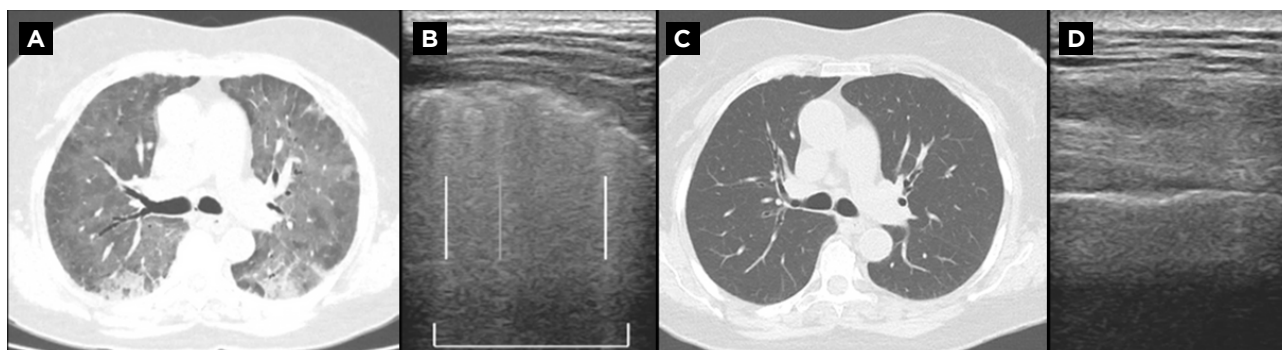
Baseline and Follow-up Imaging in MTX-Associated Pneumonitis. Axial high-resolution chest computed tomography and lung ultrasound showing findings consistent with methotrexate-associated pneumonitis (1A, 1B), with follow-up images demonstrating resolution (1C, 1D).
